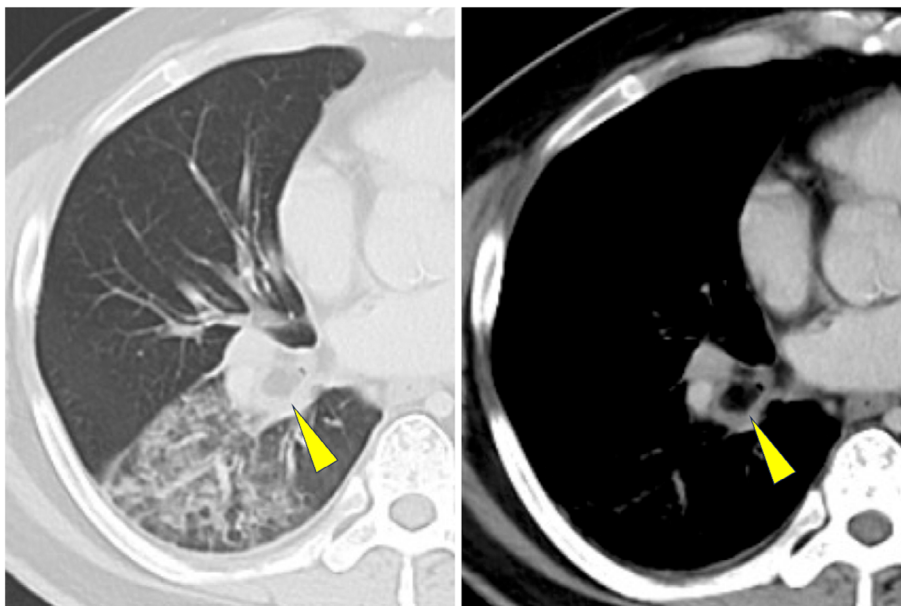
Computed tomography showing infiltrating shadows in the right lower lobe, corresponding to the site of previous pneumonia. Additionally, adipose density is observed within the right lower bronchus (arrowheads).
